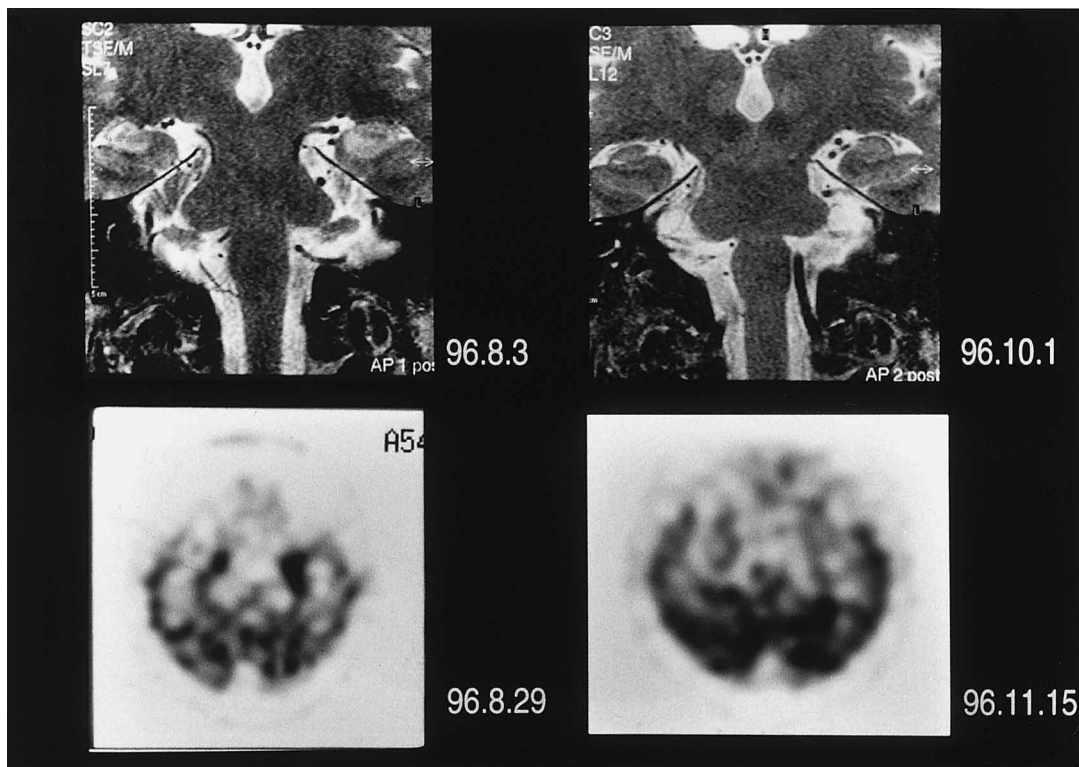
Brain imaging: Coronal T2-weighted magnetic resonance (MR) image and single-photon emission computed tomography (SPECT) image using ^{99m}Tc -hexamethyl propylene amine oxime (^{99m}Tc -HMPAO). The left side of the image corresponds to the right side of the actual brain.
